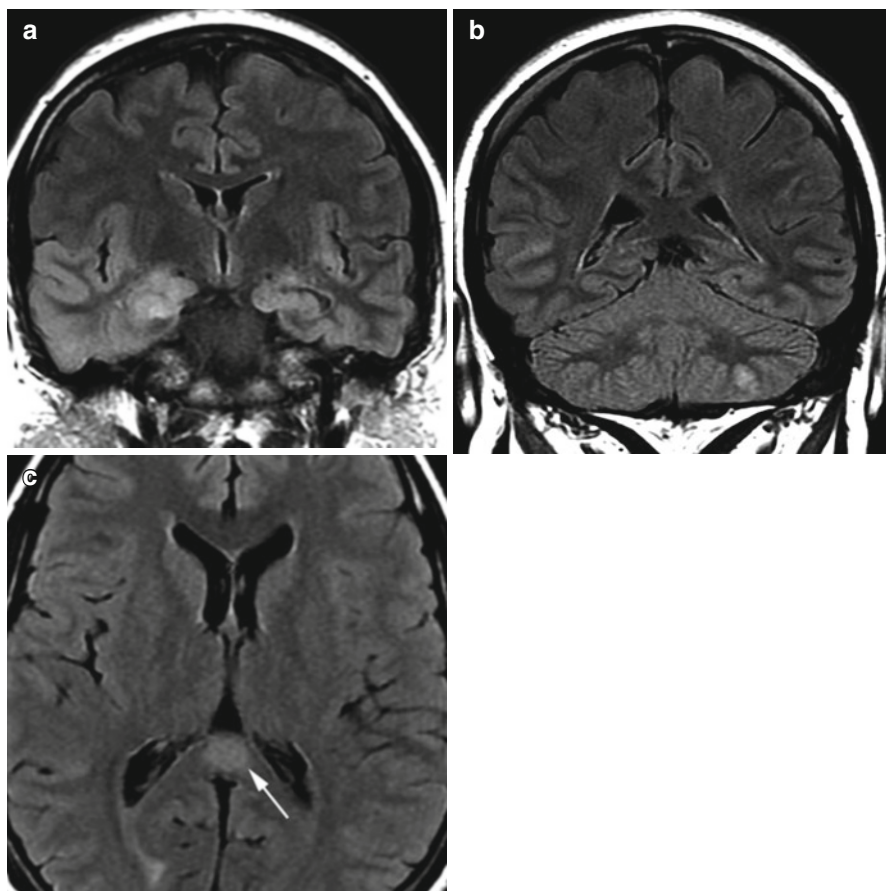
Transient postictal changes. (a) Coronal FLAIR images demonstrate bilateral high signal in temporal lobes, more pronounced on the right with associated swelling of the hippocampus. (b) Cortically based high signal in contralateral cerebellar hemisphere, likely due to a crossed cerebellar diaschisis. (c) FLAIR images in a different patient demonstrating a postictal lesion in the splenium of a corpus callosum (*arrow*)
